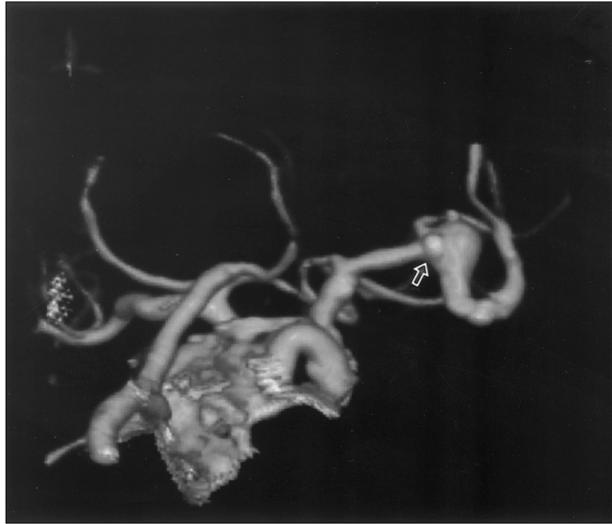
CT angiography reveals calcified atheroma on the neck of the middle cerebral artery aneurysm (arrow).
